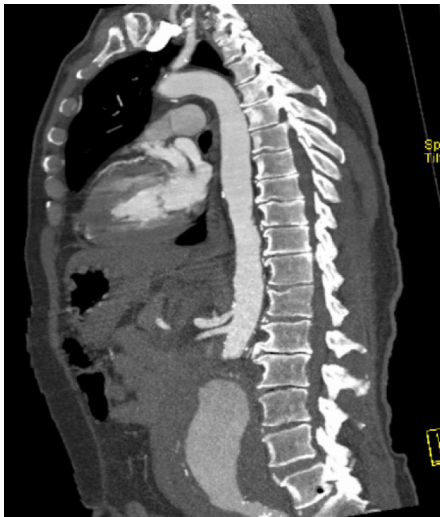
A sagittal CT scan view
